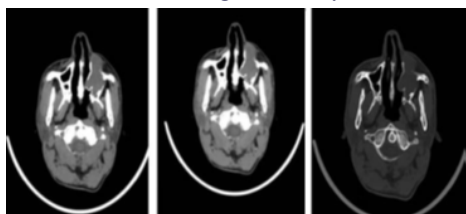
Squamous cell carcinoma: CT images show soft tissue enhancing mass in left maxillary sinus with bony destruction of surrounding walls and extra sinus extension.
